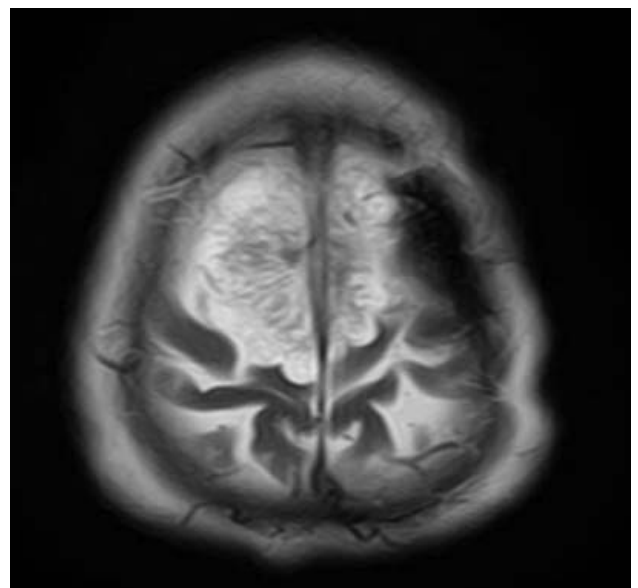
T2 weighted MR image of brain in patient with meningioma demonstrating broad base extra-axial T2 hyperintense mass arising from midline falx at vertex with feeding arterial branches diverging radially into lesion giving sunburst/spokewheel appearance.
